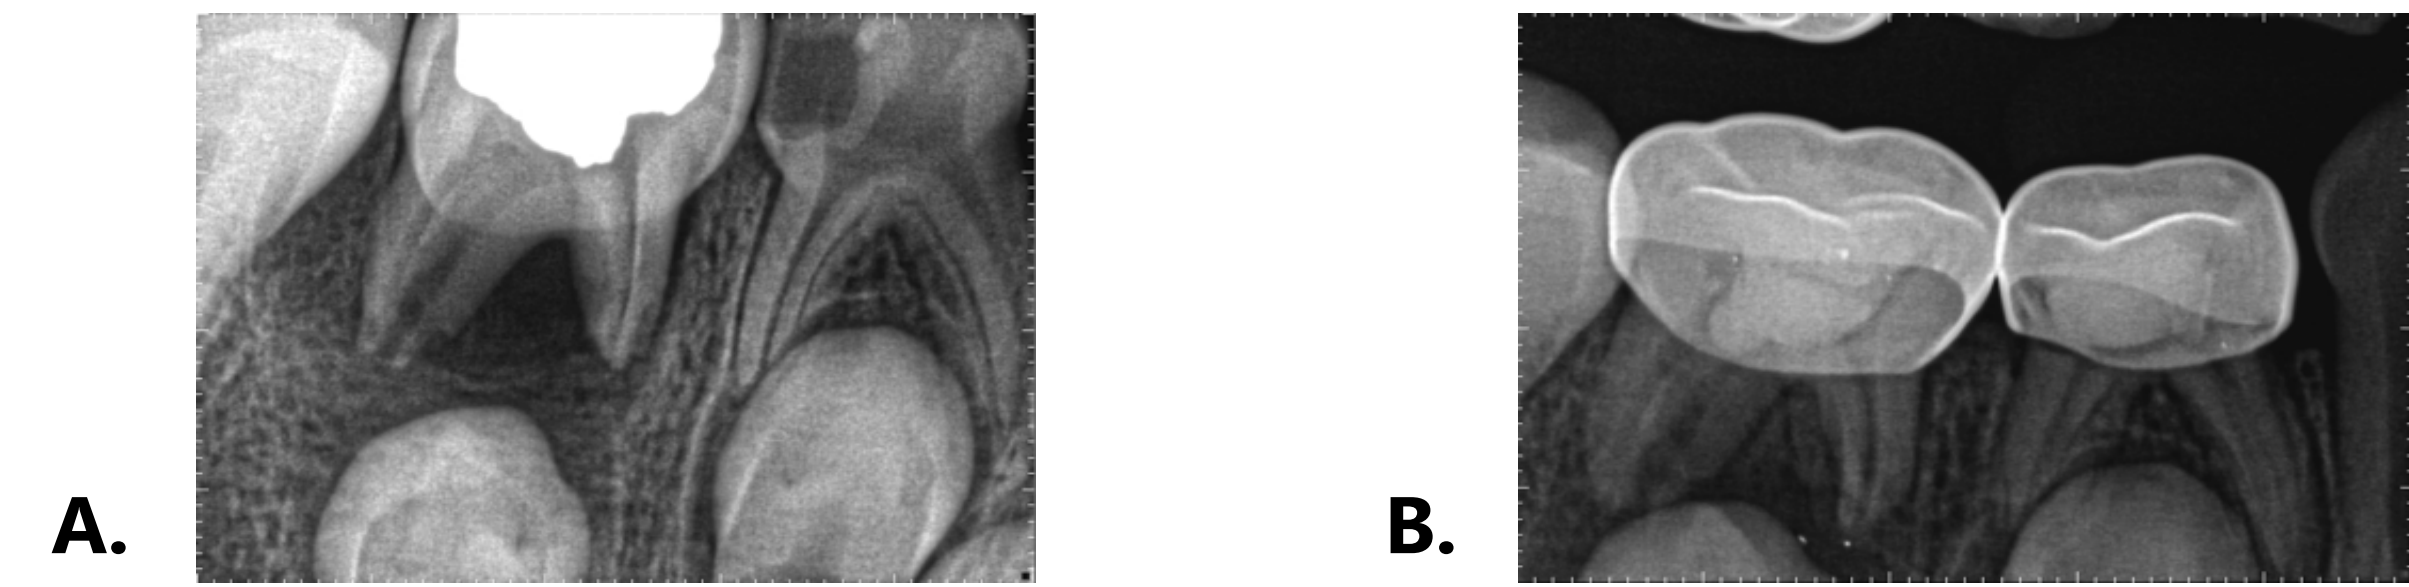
Radiographs of a subject who received LSTR treatment on teeth #T. Figure 1A is a radiograph prior to LSTR treatment. Figures 1B is a radiograph taken 6 months after treatment demonstrating osseous formation in the furcation of tooth #T and maintenance of space for succedaneous tooth.
